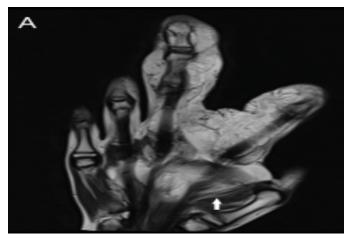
Magnetic resonance imaging of the right hand, T1-weighted sequence in coronal section showing hypertrophy of the palmar subcutaneous fat, as well as that of the 2^{nd} and 3^{rd} fingers, associated with adipose infiltration of the branches of the median nerve and of the muscles of the hand, which contain areas in T1 hypersignal (white arrow).
